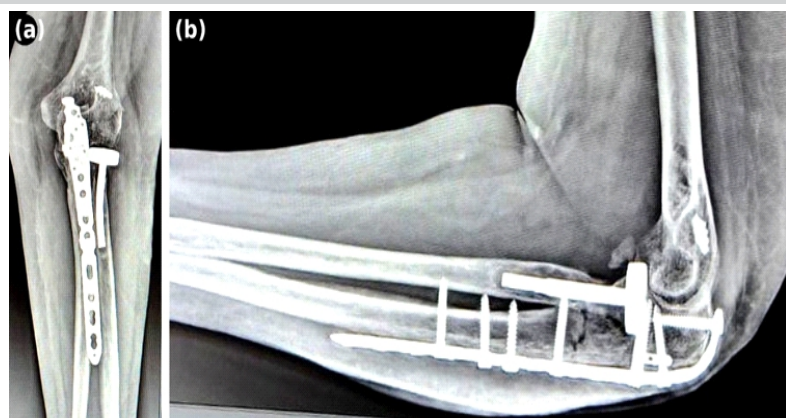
Post-operative plain radiographs at 6 weeks. (a) Anteroposterior view showing the ulnar locking compression plate in satisfactory position with the uncemented radial head prosthesis seated concentrically at the radiocapitellar joint. (b) Lateral view confirming maintained ulno-humeral congruence, appropriate anterior prosthetic positioning, and no hardware complications.
